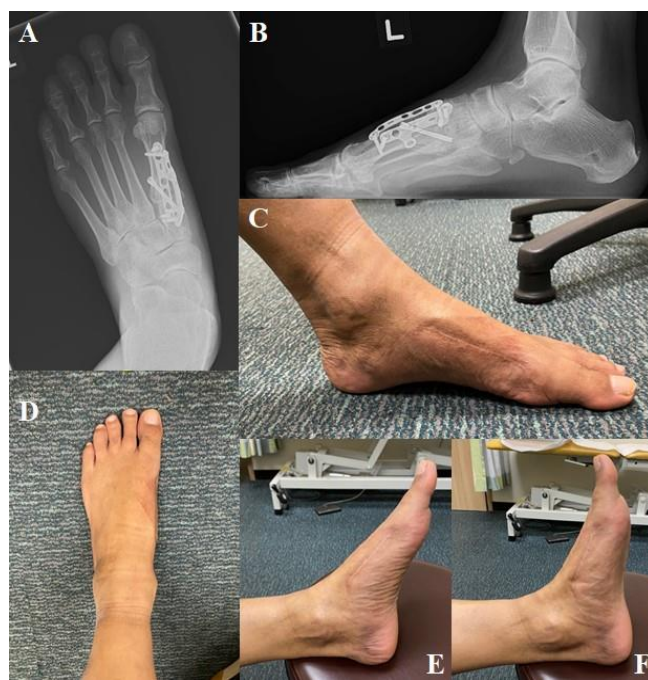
6A and 6B are radiographs of the foot at 15 months postoperatively with complete union of the first tarsometatarsal joint. 6C to 6F are clinical pictures of the left foot at 15 months with good functional ability to dorsiflex the ankle
